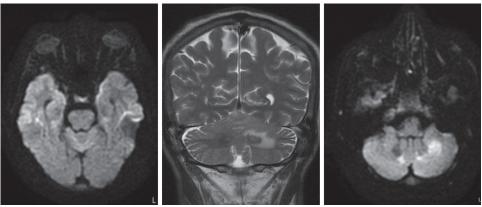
Magnetic resonance imaging showing increased signal on T2-weighted sequences and hyperintensity on diffusion-weighted sequences
